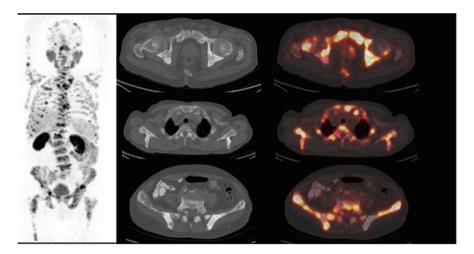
A known case of castration-resistant metastatic prostate carcinoma with ⁶⁸Ga-PSMA-11 PET/CT showing diffuse disseminated skeletal metastases involving the multiple bones of the axial and proximal appendicular skeleton
